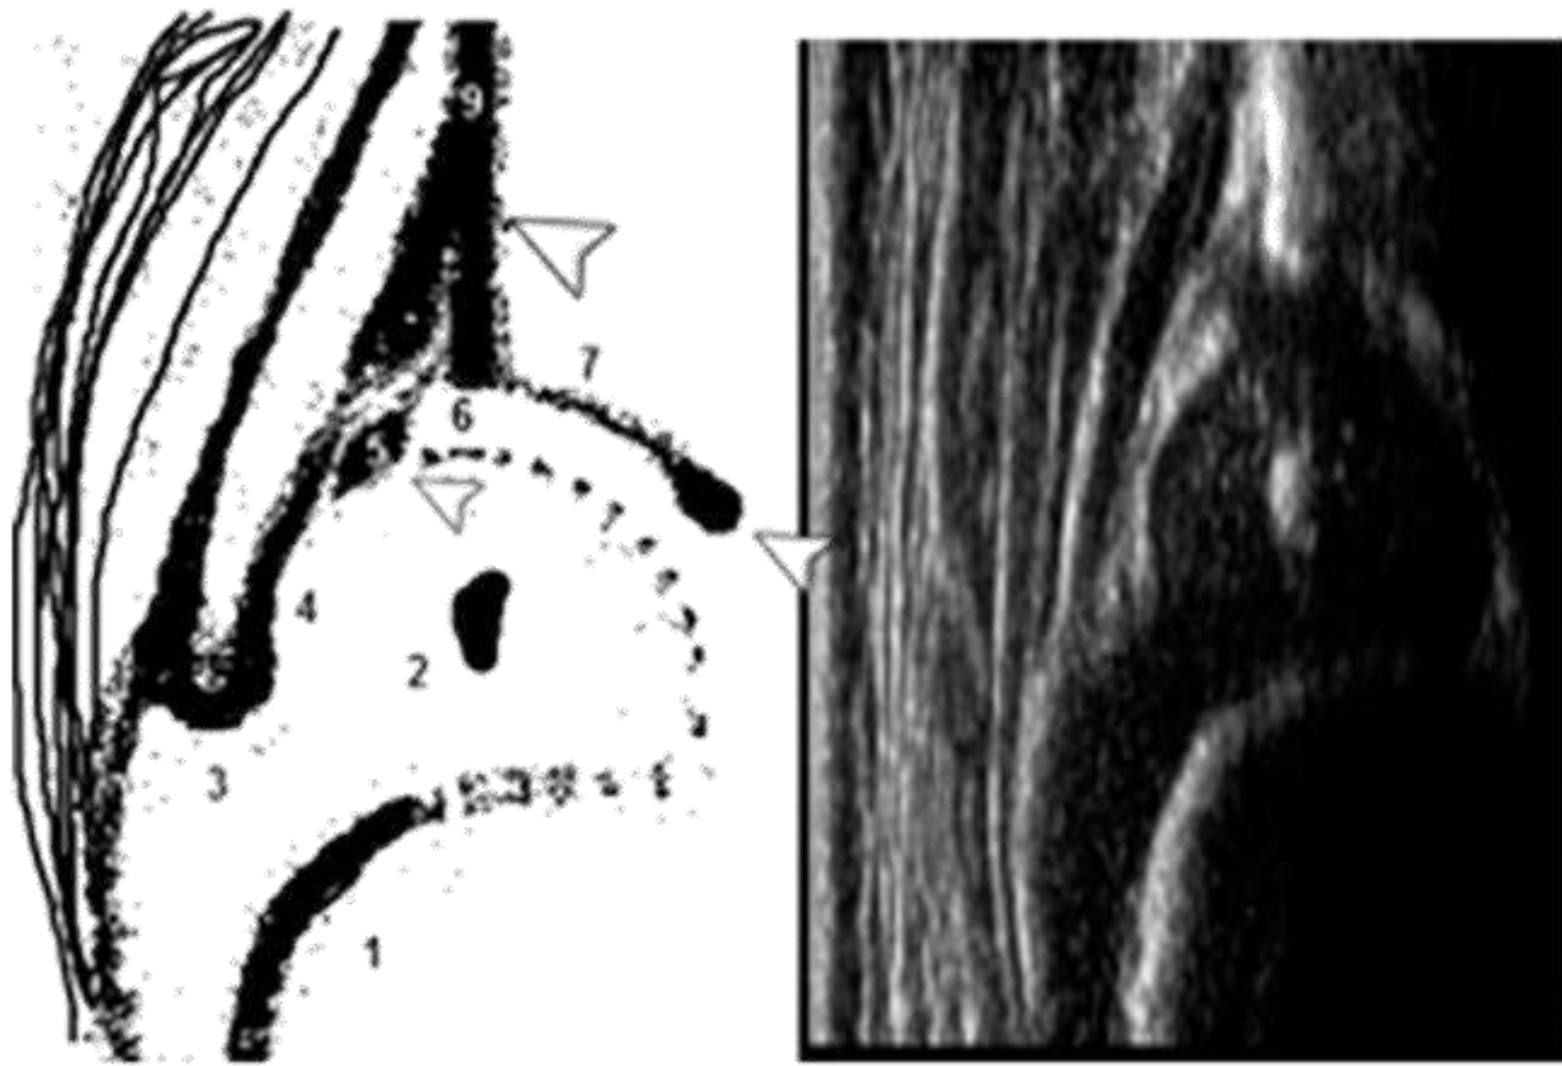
Infant hip ultrasound.
